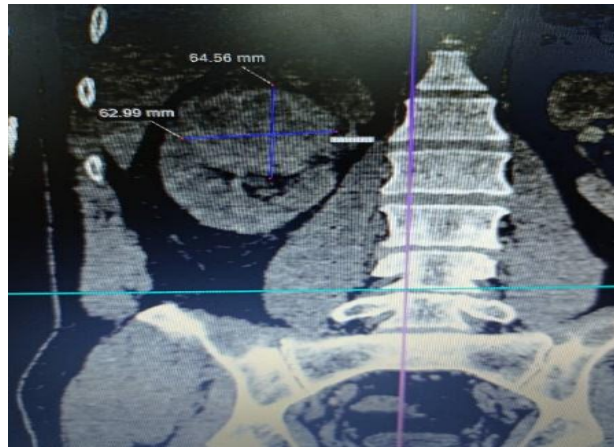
High-resolution computed tomography showing a complex, heterogeneous image that captures contrast, grows towards the renal sinus and compresses the calyces without infiltrating them. Normal renal fat.
